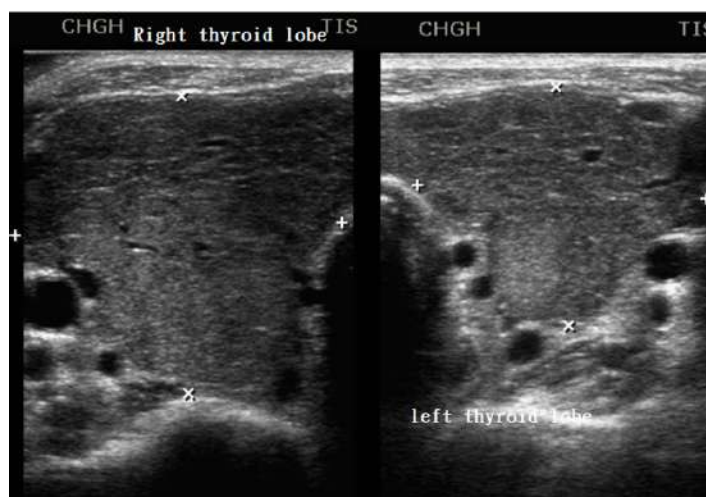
Thyroid sonography showing heterogenous background with enlarged size.
